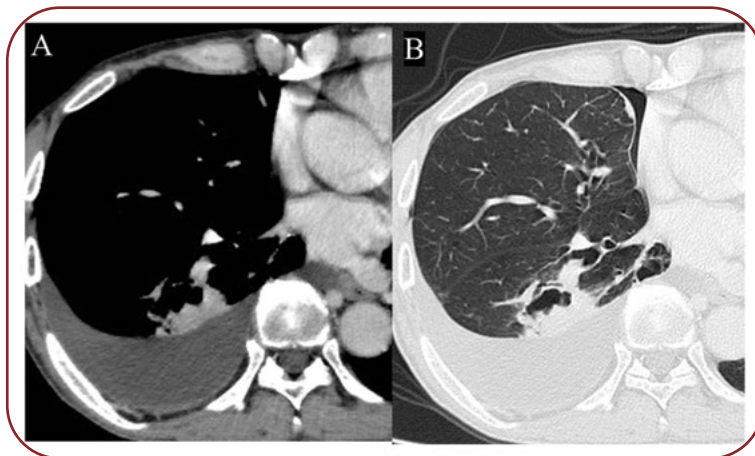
A chest computed tomography scan taken three months after the initiation of anticancer treatment confirmed the re-enlargement of the nodule in the left lower lobe and the appearance of a right pneumothorax (Figure 3-A, B). The mass had shrunk and the low-density area within the mass that had been identified before treatment had become cavity.
